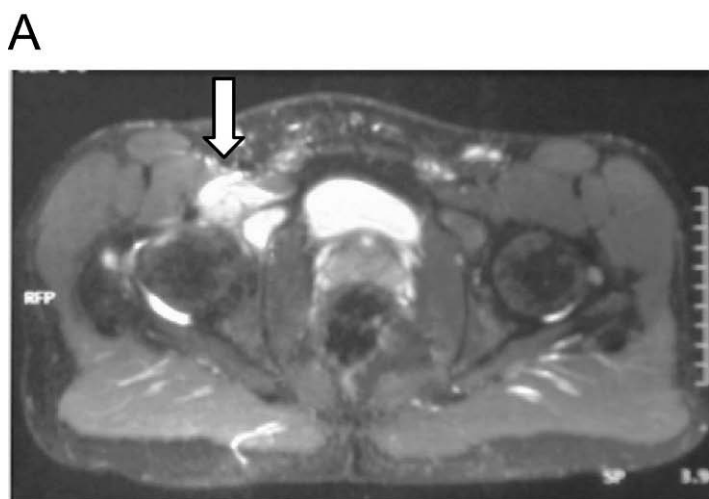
(A) and (B) Magnetic resonance images showing inflammatory signs affecting the acetabular bone and surrounding soft tissues (arrows), which were initially interpreted as suggesting a malignant pathology.
